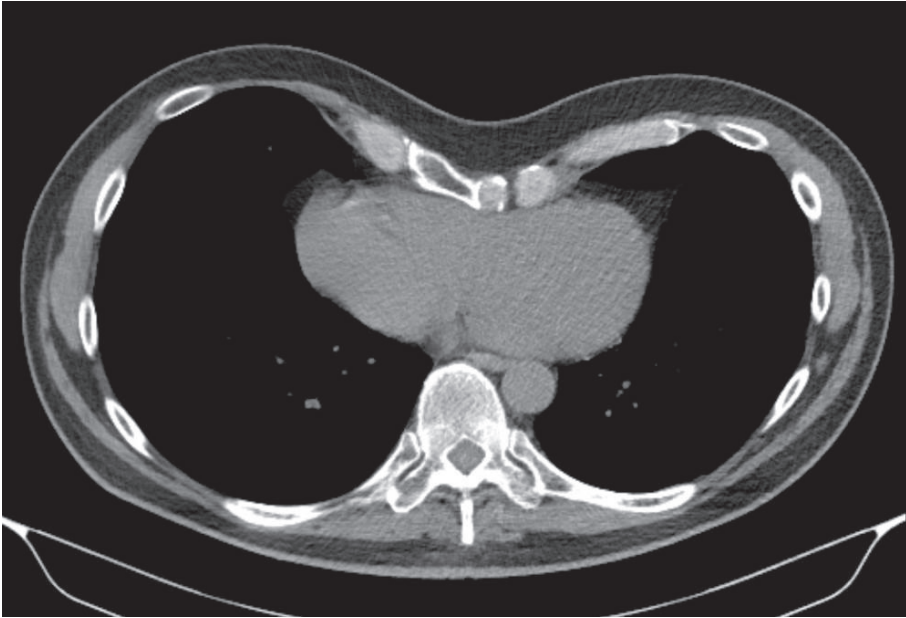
Preoperative CT-scan with cardiac impression due to depressed sternum.
